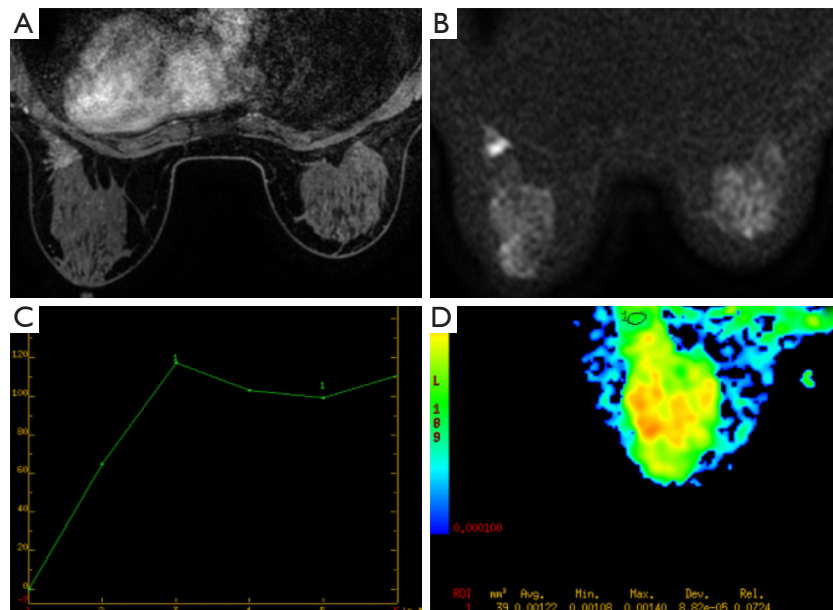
MRI imaging in a 35-year-old woman. (A) Contrast enhanced breast MRI showed focal distribution and heterogeneous enhancement; (B,C) the lesion showed persistent curve without diffusion restriction on DWI; (D) the ADC value of this benign lesion equals to $1.22 \times 10^{-3} \text{ mm}^2/\text{s}$. Final biopsy showed intraductal papilloma. MRI, magnetic resonance imaging; DWI, diffusion-weighted images; ADC, apparent diffusion coefficient.
